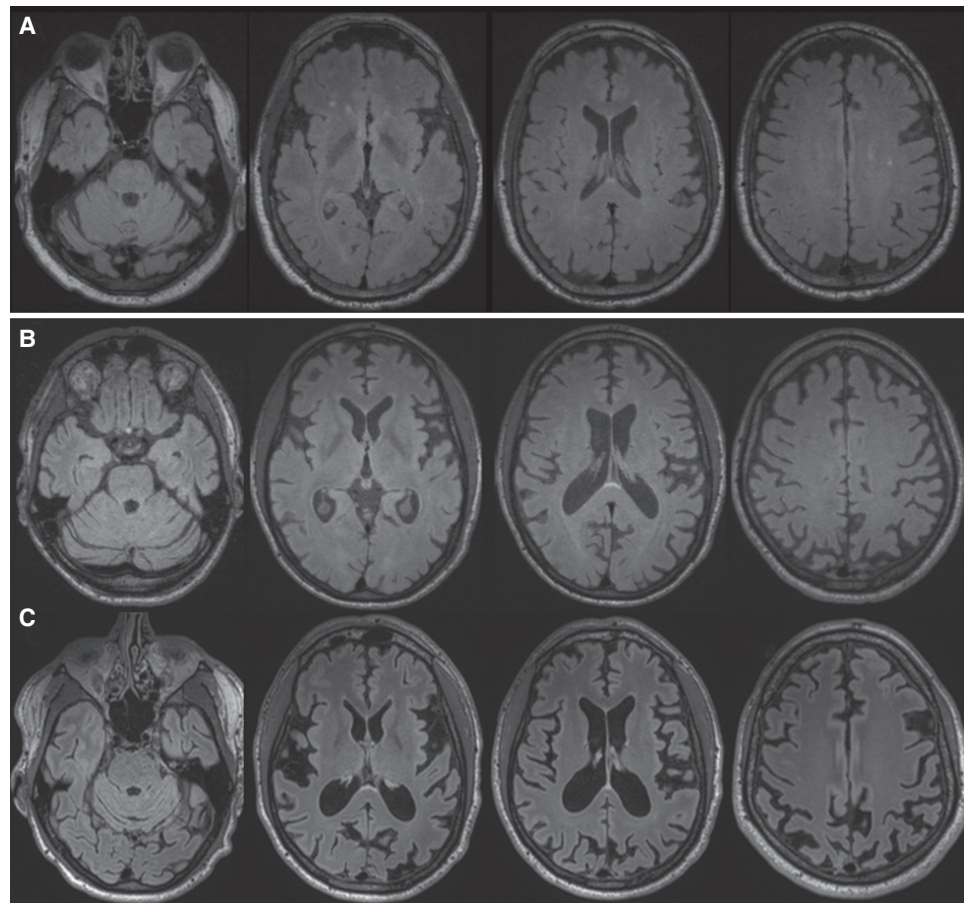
Brain magnetic resonance images (MRIs) in Slow forms of genetic prion disease (gPrD). (A) Fluid-attenuated inversion recovery (FLAIR) brain MRI in a 57-yr-old patient with P102L gPrD possibly 16.5 yr after onset (precise age of onset unclear because of comorbidities) shows mild cerebellar atrophy but no cortical atrophy or typical T2-weighted or diffusion weighted imaging (DWI) hyperintensities (cortical ribboning or deep nuclei hyperintensity), but only several punctate hyperintensities in the white matter consistent with small vessel ischemic vascular disease. DWI/attenuation diffusion coefficient (ADC) map sequences showed no restricted diffusion (not shown). (B) FLAIR brain MRI of with 37-yr-old gPrD 6-octapeptide repeat insertion (OPRI) patient showing diffuse cortical atrophy only 7 mo after reported clinical onset; the amount of atrophy suggests that the disease began years before obvious clinical onset. DWI and ADC map sequences showed no restricted diffusion (not shown). (C) Repeat brain MRI on the same 6-OPRI patient 25 mo later, 32 mo after clinical onset, shows the progression of atrophy. DWI and ADC map sequences still showed no restricted diffusion (not shown). Orientation is radiological. (Reprinted from Takada et al. 2017.)
